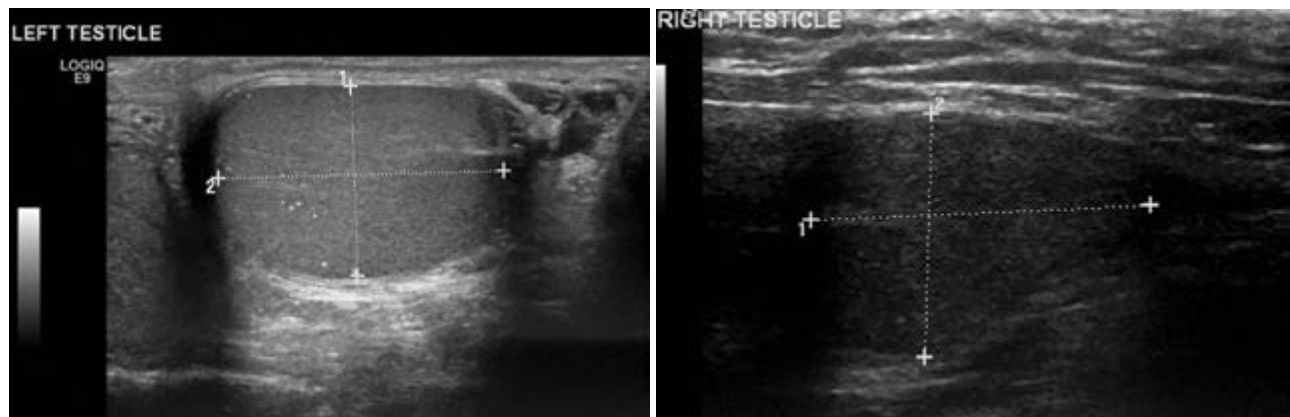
Classic grade I microlithiasis of the left testis, in a 20 - year old man with a history of right cryptorchidism. Scrotal ultrasound; (a) the longitudinal section of the left testis reveals the presence of five microliths within its parenchyma. (b) the longitudinal section of the right testis shows this to be smaller and with hypoechoic imaging compared to the contralateral testis.
